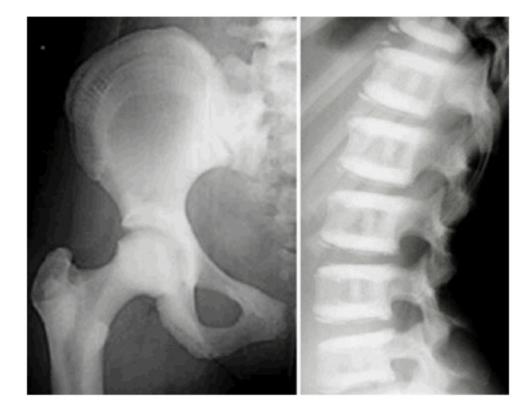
ADOII x-rays (reprinted from Benichou et al 2000 with permission from Elsevier)
